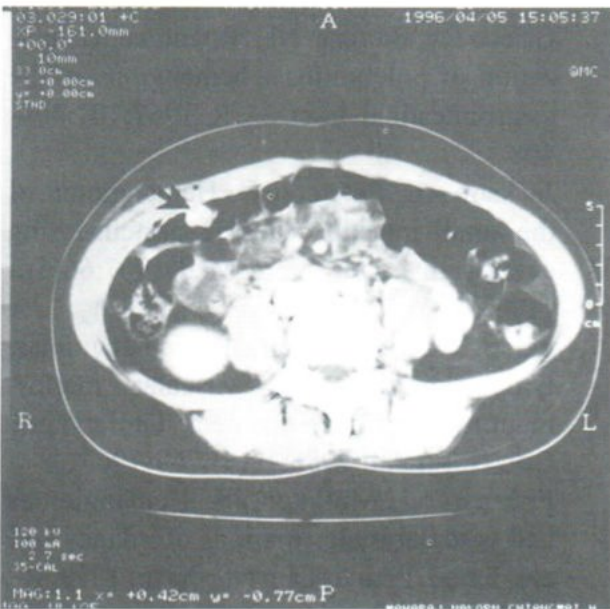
Postcontrast CT scan shows focal thickening of the ileal wall with calcifications (arrow).
